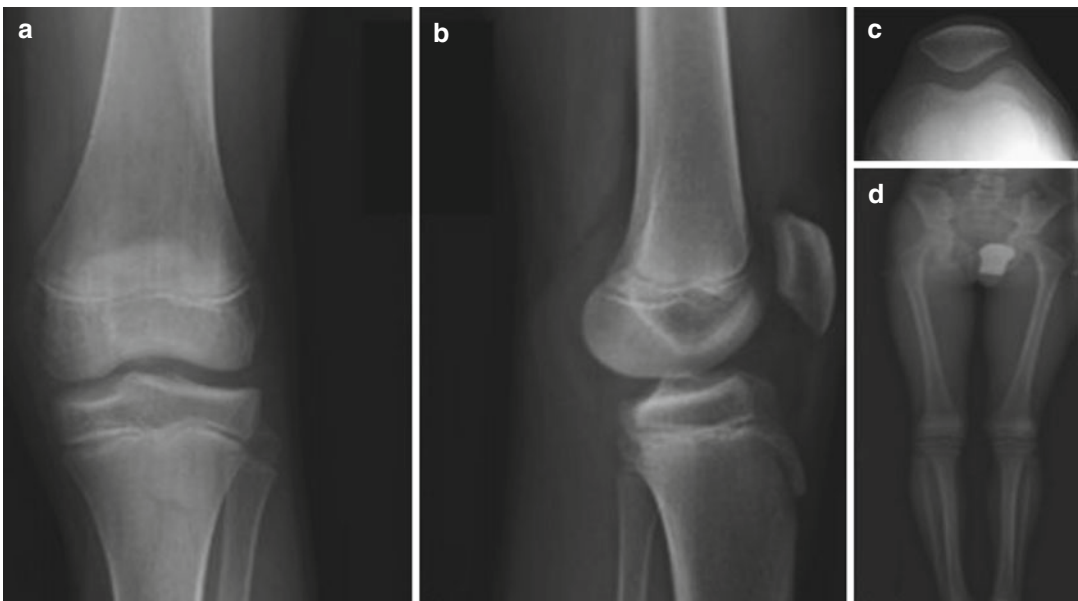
Standard radiographs for the preoperative planning of an ACL reconstruction in children: AP (a) and lateral (b) views, patellofemoral view (c), full leg view (d)
